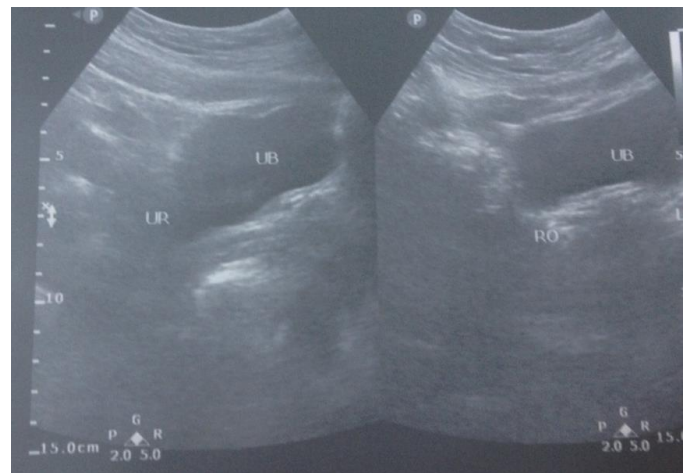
Ultrasound abdomen and pelvis
